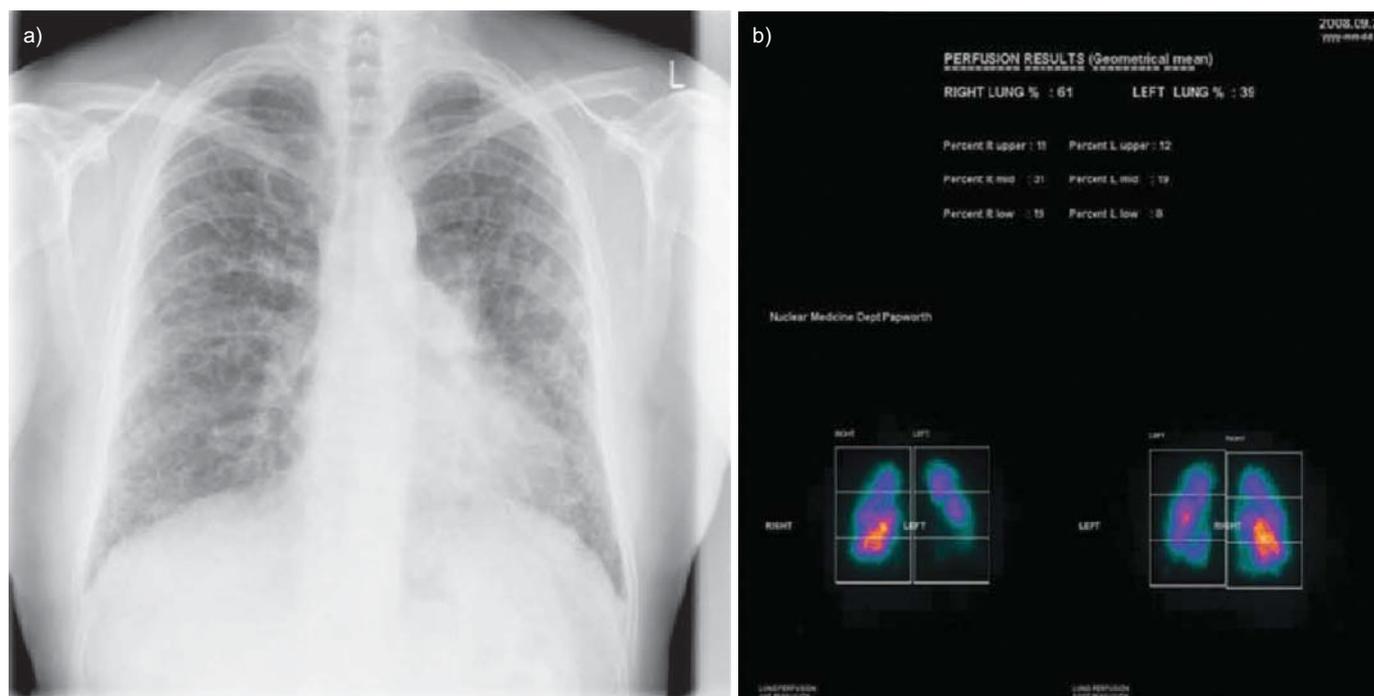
Pre-transplant a) chest radiograph and b) perfusion scan.
